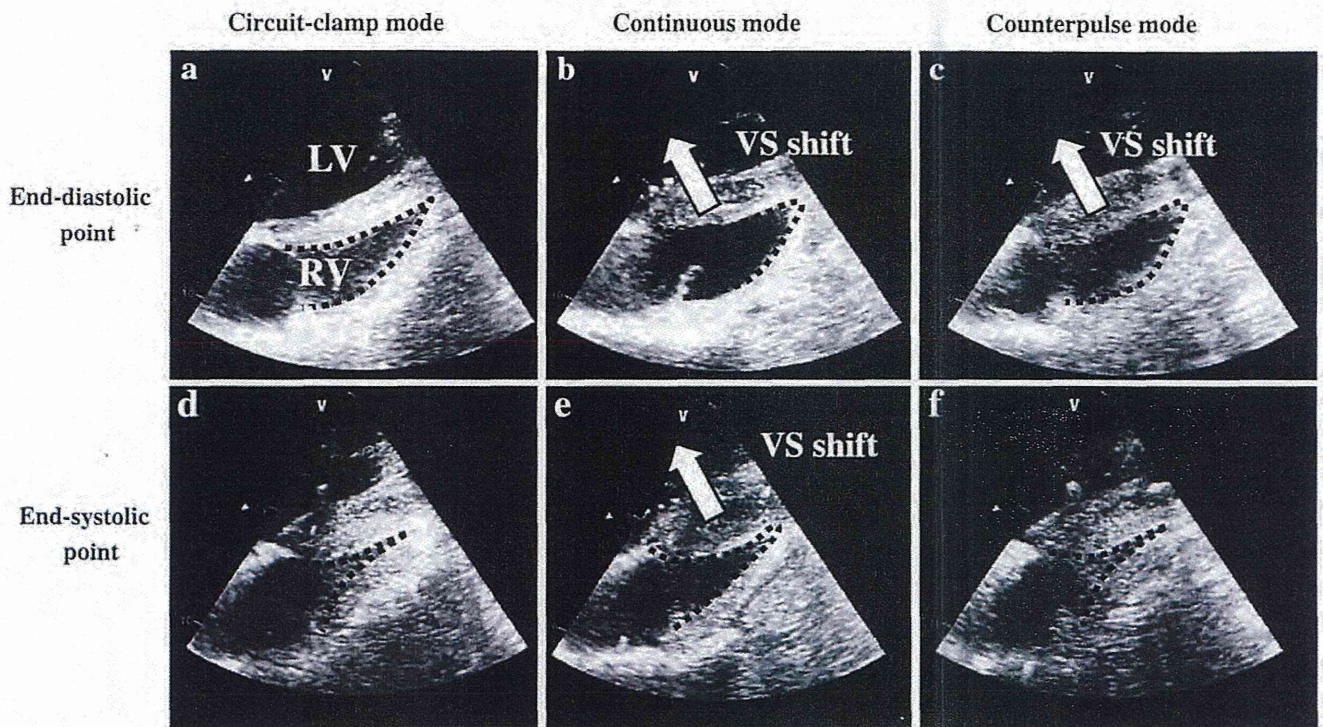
Sample echocardiograms obtained in each mode. Leftward ventricular septal (VS) shift is evident in continuous and counter-pulse modes (a, b, d, e), but corrected by decreased rotational speed during systolic phase in counter-pulse mode (c, f)
